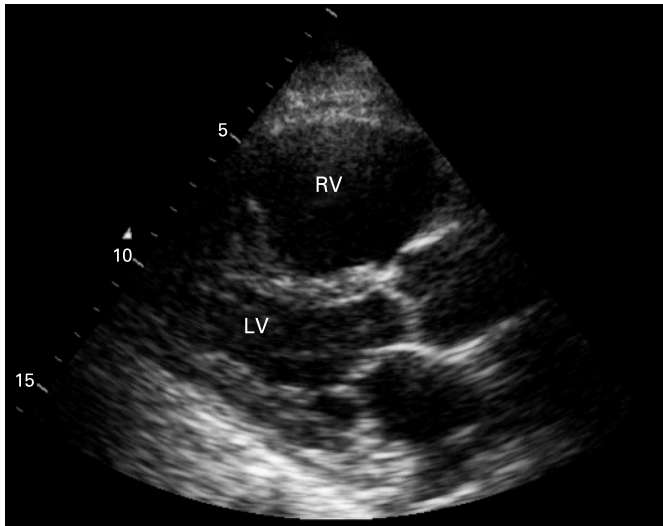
Focused cardiac scan (parasternal long-axis view) showing a dilated right ventricle (RV). LV, left ventricle.
